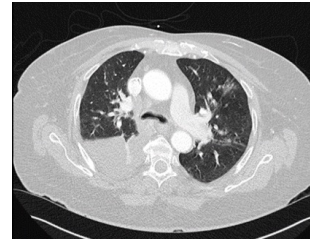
CT scan at presentation
